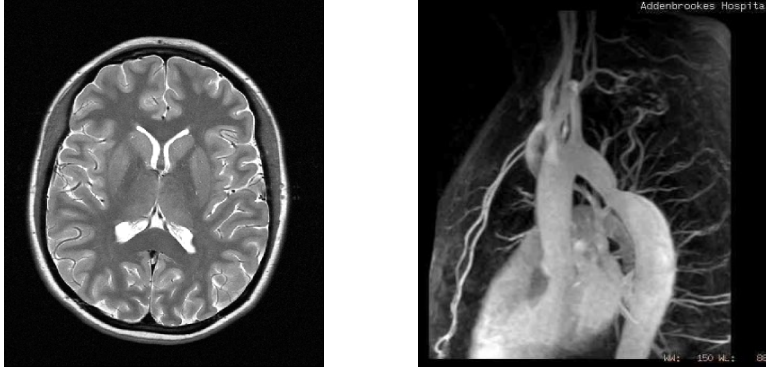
Example MRI images of the brain (left) and heart (right).
